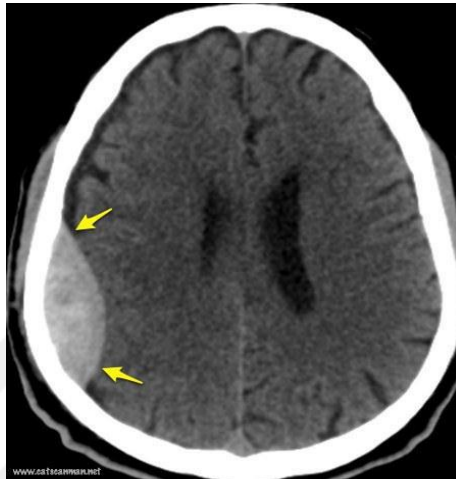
CT Brain Epidural Hematoma [29].
